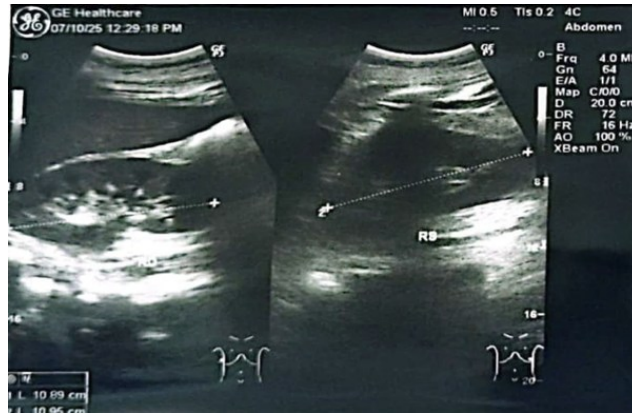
Abdominal ultrasound demonstrated bilateral parenchymal renal disease
